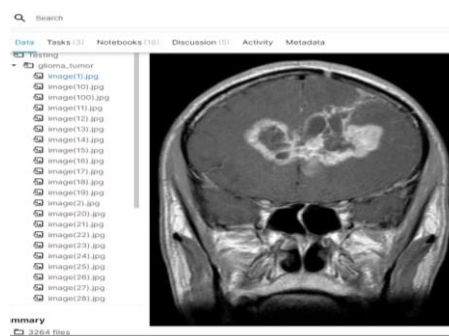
One sample of enlarge MRI Images
